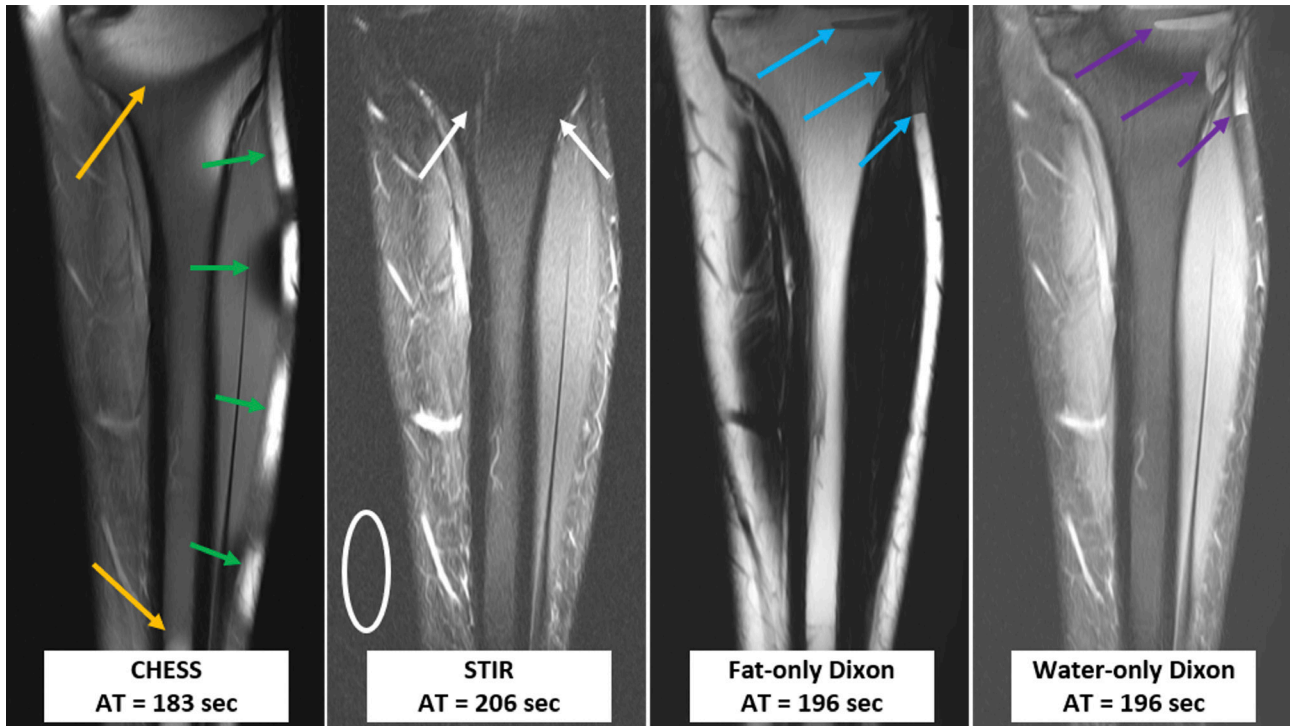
MR images of the calf in a 26-year-old man demonstrate the potential utility of Dixon FSE in the setting of large FOV imaging. On CHES, the typical pattern of failed FS occurs along the superior and inferior margins of the FOV (gold arrows) and along the lateral periphery of the FOV which is furthest from magnet isocenter (green arrows). On STIR, the typical appearance of shading artifact along the superior FOV is demonstrated (white arrows). Note that the typical alternating-band appearance of failed FS on water-only Dixon (purple arrows) involves a smaller area than failed FS on the CHES sequence. In addition, the areas of failed FS on water-only Dixon are still viewable on the fat-only images (blue arrows). STIR demonstrates decreased SNR (white oval) relative to CHES and water-only Dixon. The fat-only Dixon sequence provides potential additional utility in marrow assessment. AT = acquisition time.
